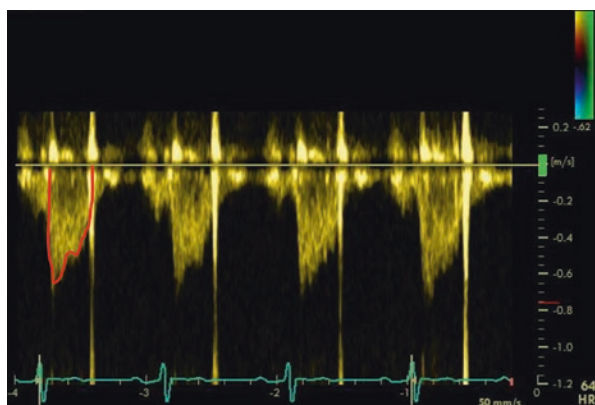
Pulsed wave Doppler with sample in right ventricle outflow tract
